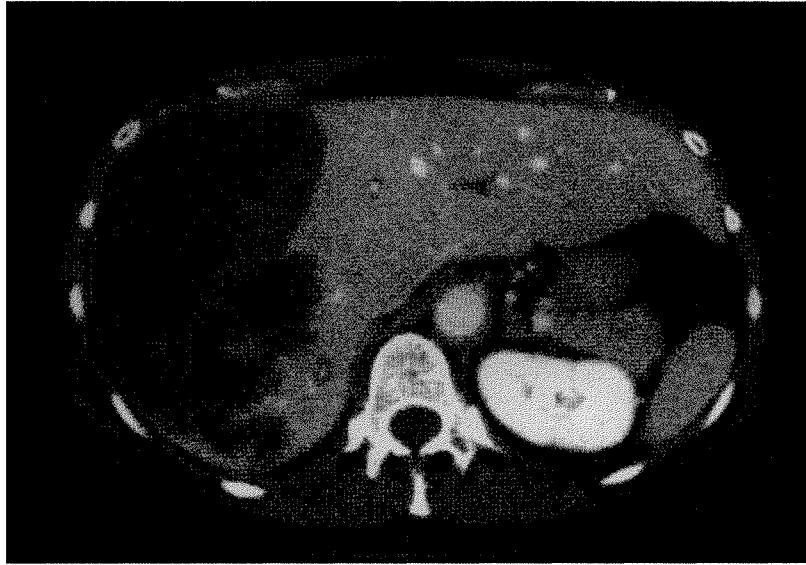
Follow-up CT scan 10 days after embolization showing low density hematoma and irregular low density regions in the posterior aspect of the right lobe secondary to hepatic infarction and necrosis.
